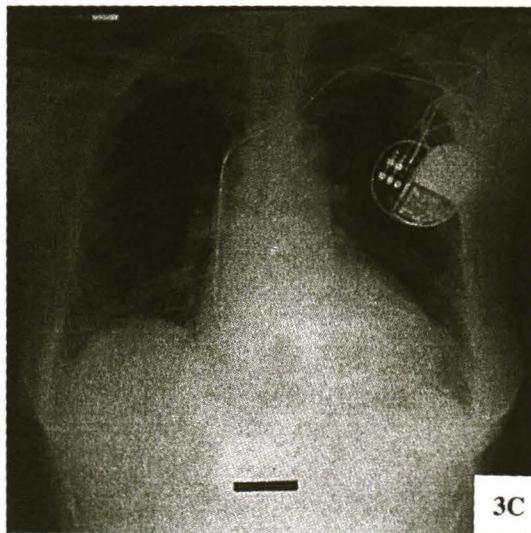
Chest X-ray at 6 months after implantation with reduction in cardiac shadow.
